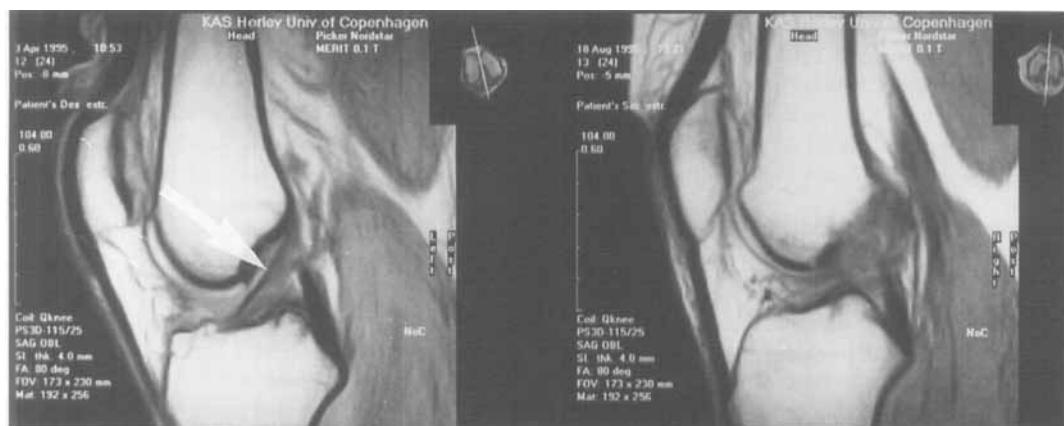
Sagittal T1-weighted image showing the normal anterior cruciate ligament as a band of low signal intensity (arrow), almost parallel to the femoral intercondylar roof.
